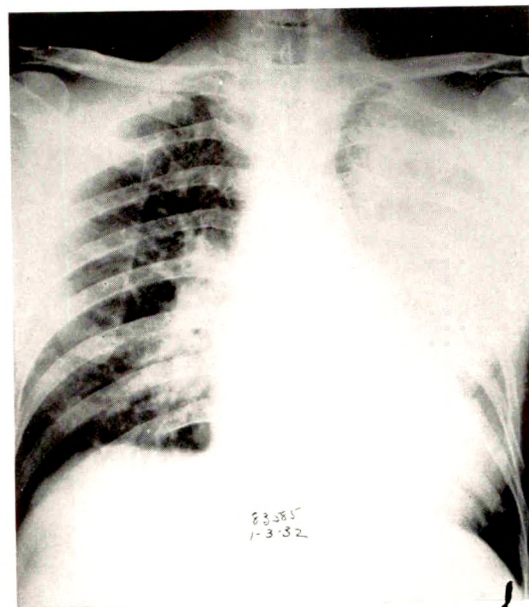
Posterior roentgen examination the following day showing dense consolidation of the left lung due to traumatic pneumonia. Course and resolution were uneventful. Pneumonic involvement was near site of injury.
